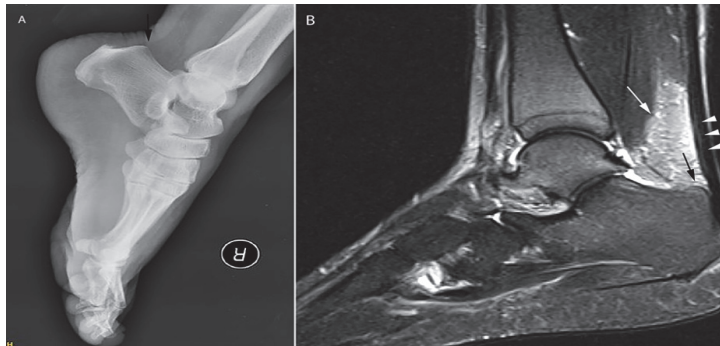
Prominence in the bone at the posterior upper part of calcaneus at direct X-ray (black arrow). Figure 1B. Magnetic resonance imaging (T2 sagittal section) demonstrates prominence in the bone at superoposterior calcaneus (black arrow), signal increase in the Achilles tendon compatible with fluid (white arrow heads) and hyperintensity in the kager fat pads (white arrow).
